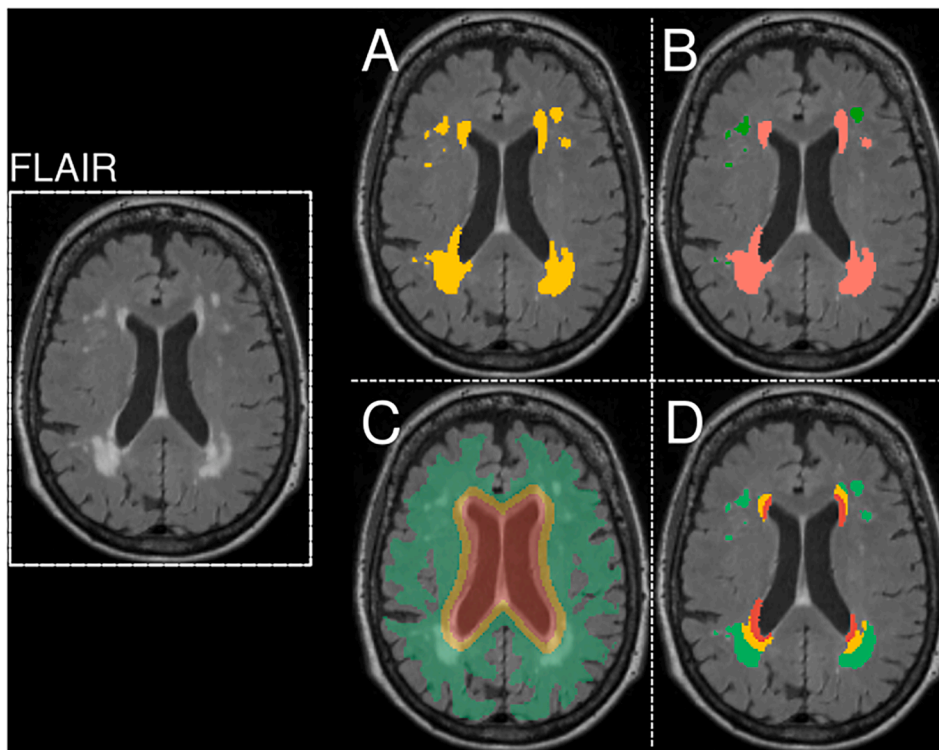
White matter hyperintensity segmentation and classification schemes. White matter hyperintensities were automatically segmented from FLAIR MRI. A single axial slice of the FLAIR image is shown on the left for a given subject in template space. (A) The WMH segmentation for this subject is shown in yellow. (B) An example of the periventricular/deep classification scheme is shown for the WMH in a given subject. WMH were classified as “periventricular” if the minimum distance of a lesion volume from the lateral ventricles was <5.0 mm in subject space or if the average distance of a continuous lesion was <20.0 mm from the lateral ventricles. WMH were otherwise classified as “deep”. (C) Regions of interest were defined by repeatedly dilating a ventricular mask obtained from the population template brain. The first region (Region 1) is shown in red, and included an area 10 mm or less from the lateral ventricles in all directions. Region 2 is shown in yellow, and was defined by further dilating Region 1 to obtain an area between 10 mm and 20 mm from the lateral ventricles. Region 3, shown in green, consisted of all remaining white matter beyond 20 mm from the lateral ventricles. (D) Lesions were classified into these distance-based classes according the Region with which they overlapped. (For interpretation of the references to colour in this figure legend, the reader is referred to the web version of this article.)
